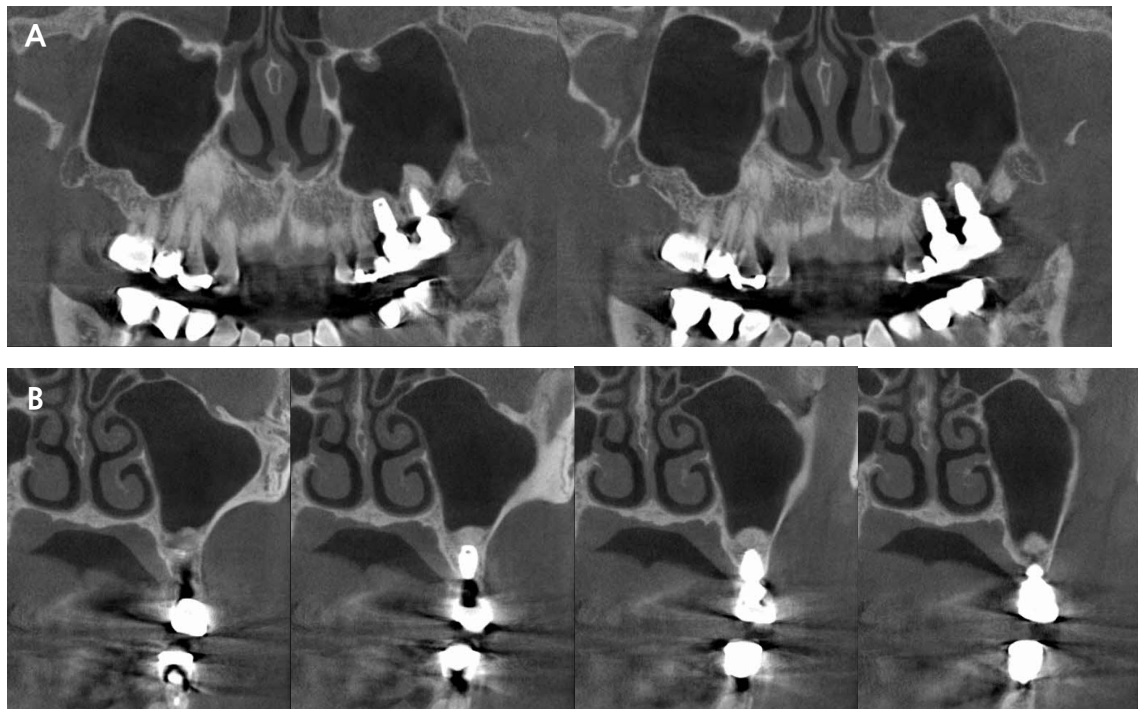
CBCT radiographs of crown delivery after 6 months. (A) panoramic view, (B) Paraxial view.
